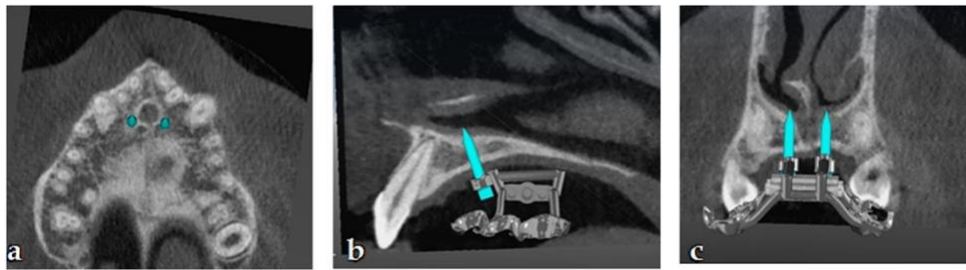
Bicortical anchorage of miniscrews using CBCT guidance in a superior, b lateral and c posterior views. [Adapted from (26)]
